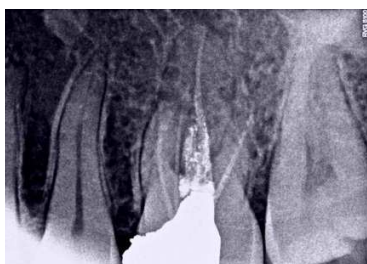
Preoperative Periapical radiograph of Left Maxillary First Molar
